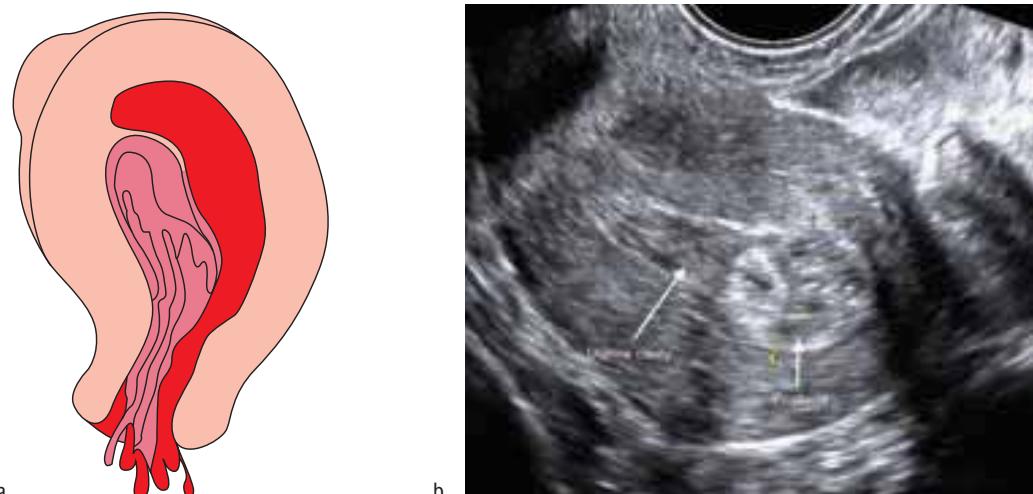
Incomplete miscarriage. a. Products of conception have been partially expelled. b. Ultrasound image showing retained products of conception in the upper part of the uterine cavity. (Photo courtesy: Mediscan Systems, Chennai.)
